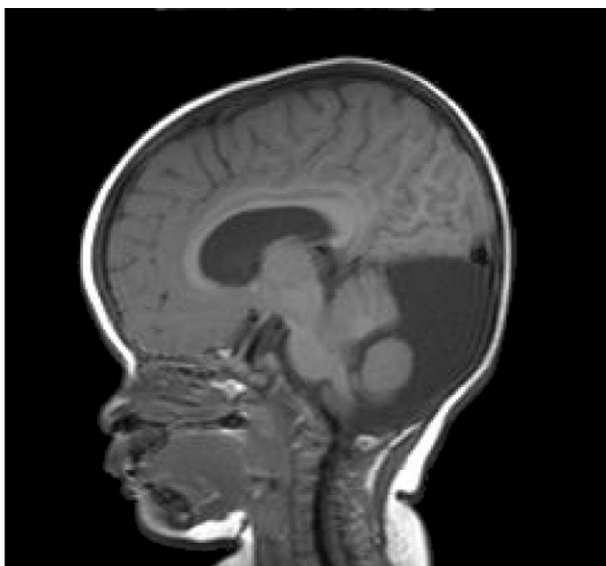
Magnetic resonance imaging 6 mo postsurgery follow-up. The hydrocephalus had improved and cyst had shrunk compared with those in Figure 2.
